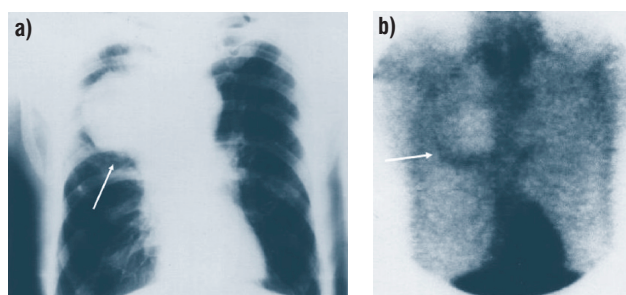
Findings in a patient with squamous cell carcinoma: a) round tumor mass (arrow) in the right upper lobe of the chest X-ray; b) ring-like uptake of ^{99m}Tc -sestamibi in the right upper lobe indicating tumor necrosis (arrow).
